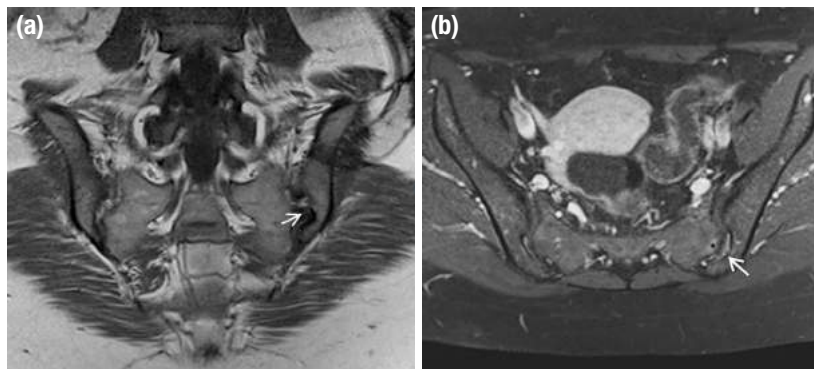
a, b. Left accessory SIJ (arrows) was observed on paracoronar T1-weighted (a) and contrast-enhanced fat-saturated T1-weighted (b) axial images. Bone marrow edema at the sacral side and minimal sclerosis were seen in the left SIJ (asterisk).
